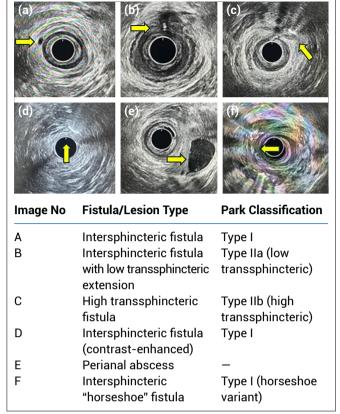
Representative imaging of perianal fistula/ lesion types according to Park classification. Panels A–F show the spectrum of common fistula anatomies and associated lesions as visualized on endoanal ultrasound (with contrast where indicated).
